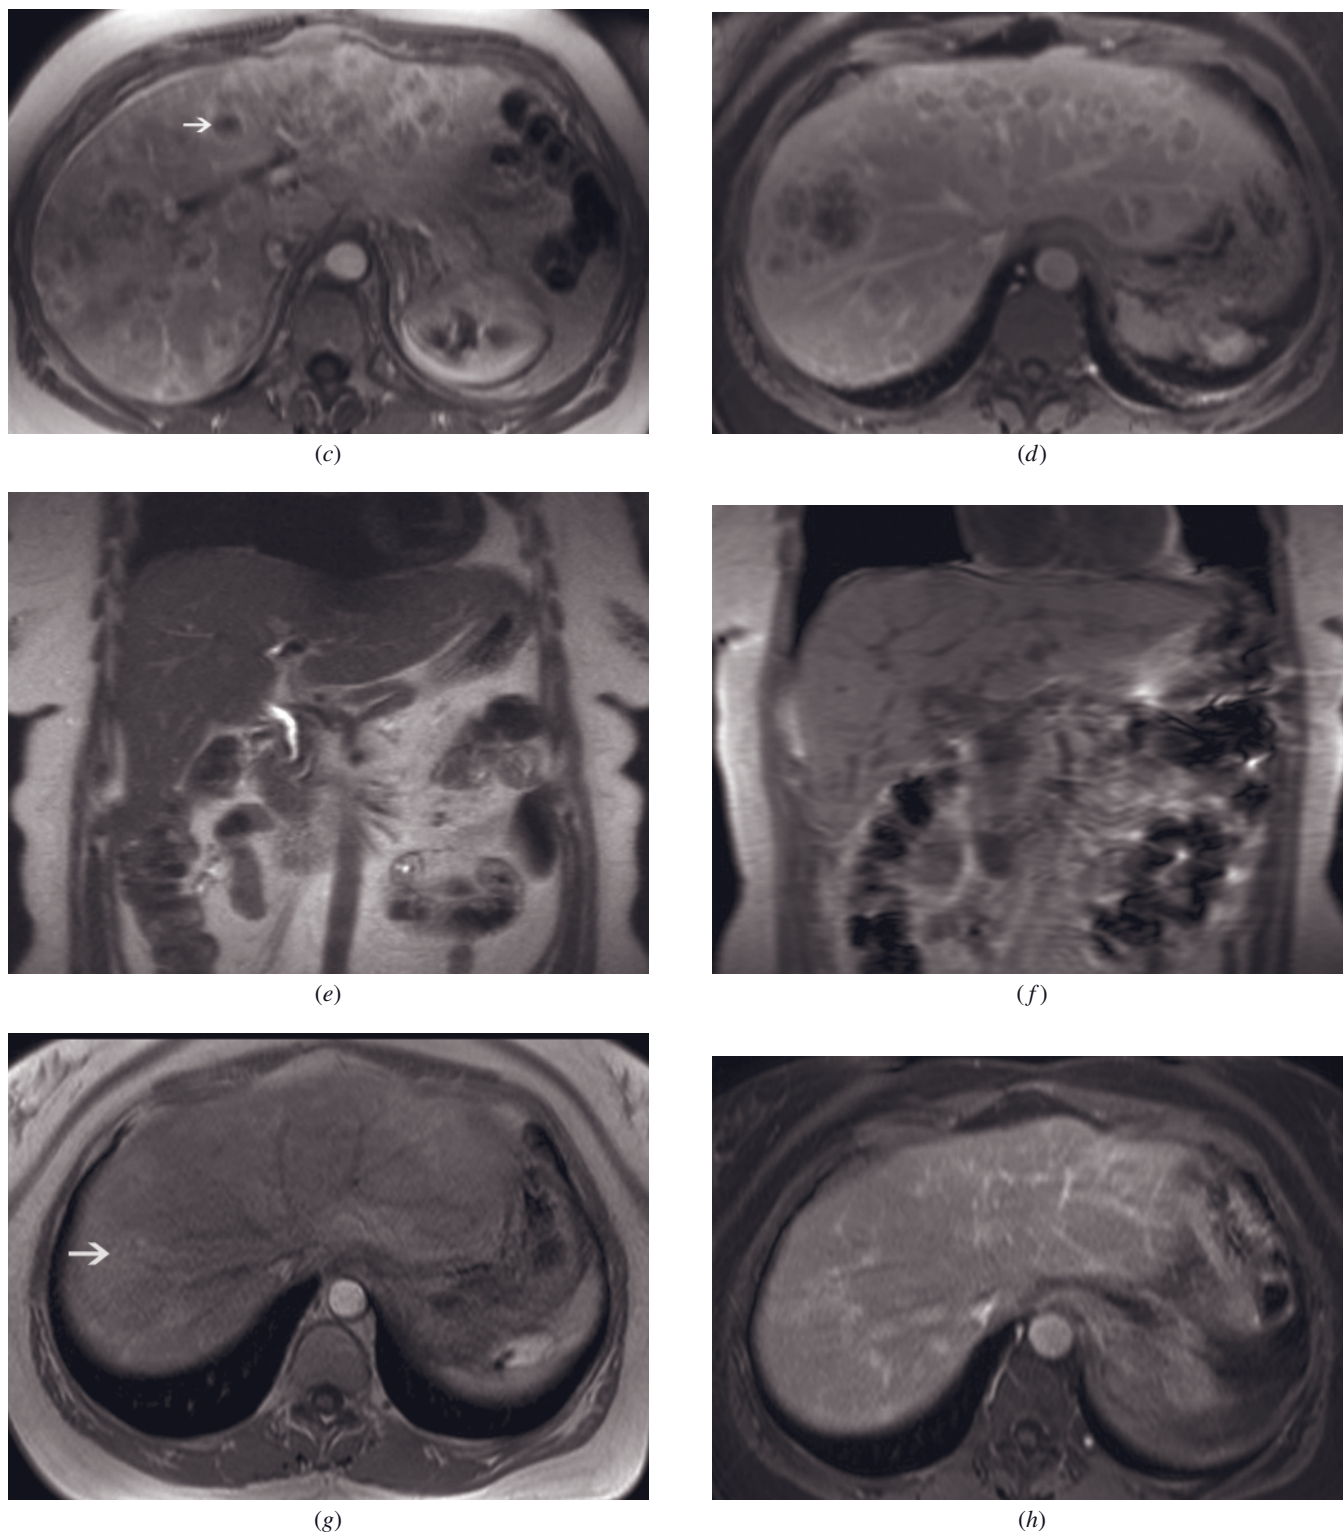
(Continued) moderately high signal intensity on T2-weighted images (a) and moderately low signal intensity on T1-weighted image (b) and show ring enhancement on early-phase image (arrow, c) that become less conspicuous on the late-phase image (d). Coronal T2-weighted SS-ETSE (e) and T1-weighted SGE (f) and transverse immediate (g) and 90-s fat-suppressed (h) postgadolinium SGE images in the same patient after a course of cycles of chemotherapy. Only patchy enhancement on early-phase images can be appreciated (arrow, g). The remaining sequences are unremarkable.
